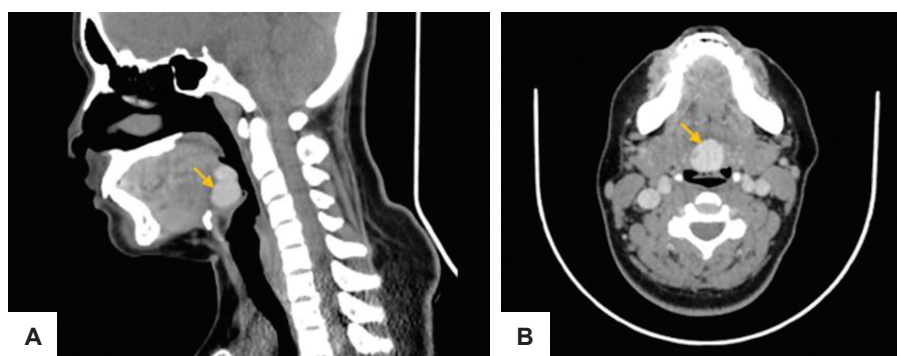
Contrast-enhanced multislice computed tomography (MSCT) of the neck demonstrated an ectopic thyroid gland at the base of the posterior tongue, shown in (A) sagittal and (B) axial views.
